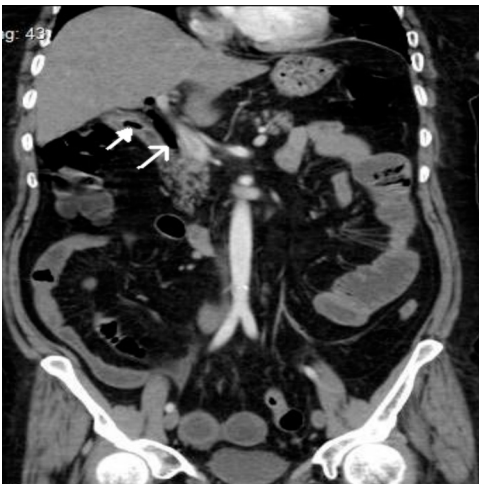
Coronal view of abdominal computed tomography (CT) image showing an abnormal Gas in the gallbladder (Close arrow) and in common bile duct (Open arrow). Pneumobilia.
